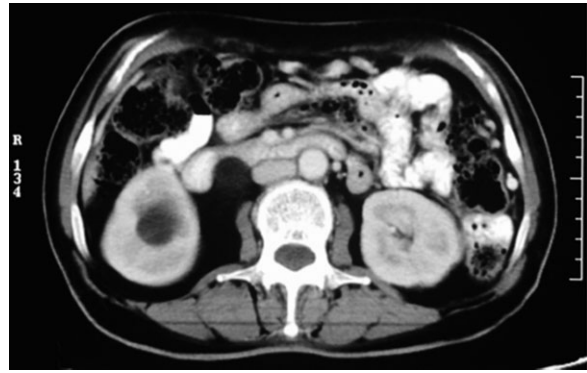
Post-chemotherapy repeat contrast-enhanced computed tomography shows significant resolution of the peritoneal implants.
